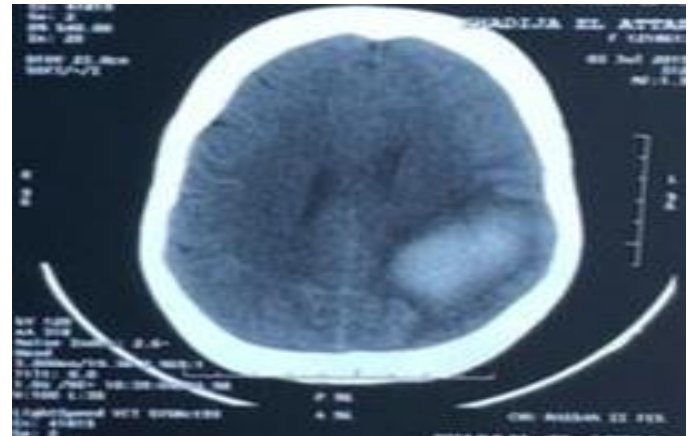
CT scan showing a left parietal hematoma
